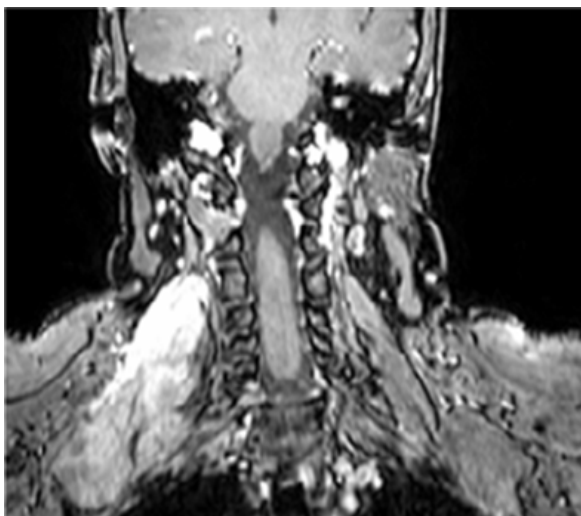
Frontal MRI sequence T1 with injection of the right cervical desmoid tumor
